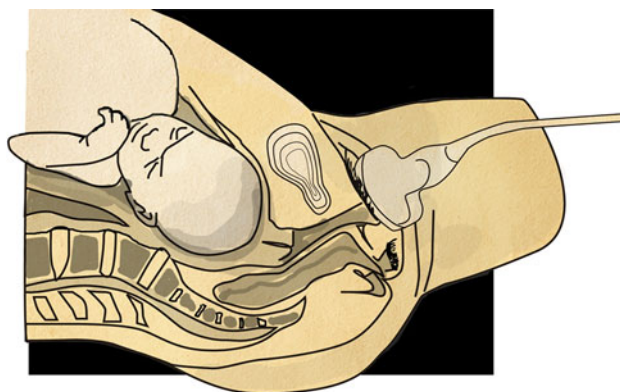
Translabial ultrasound
